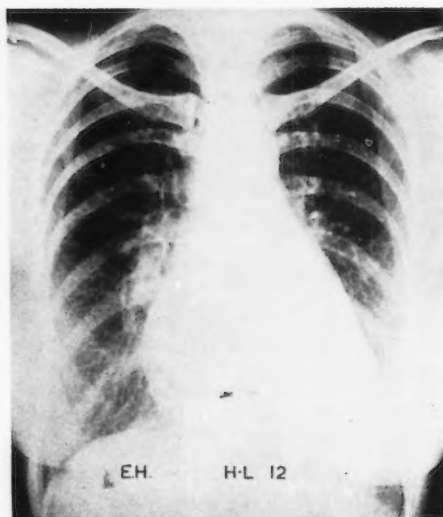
Case 8, posteroanterior chest x-ray.
